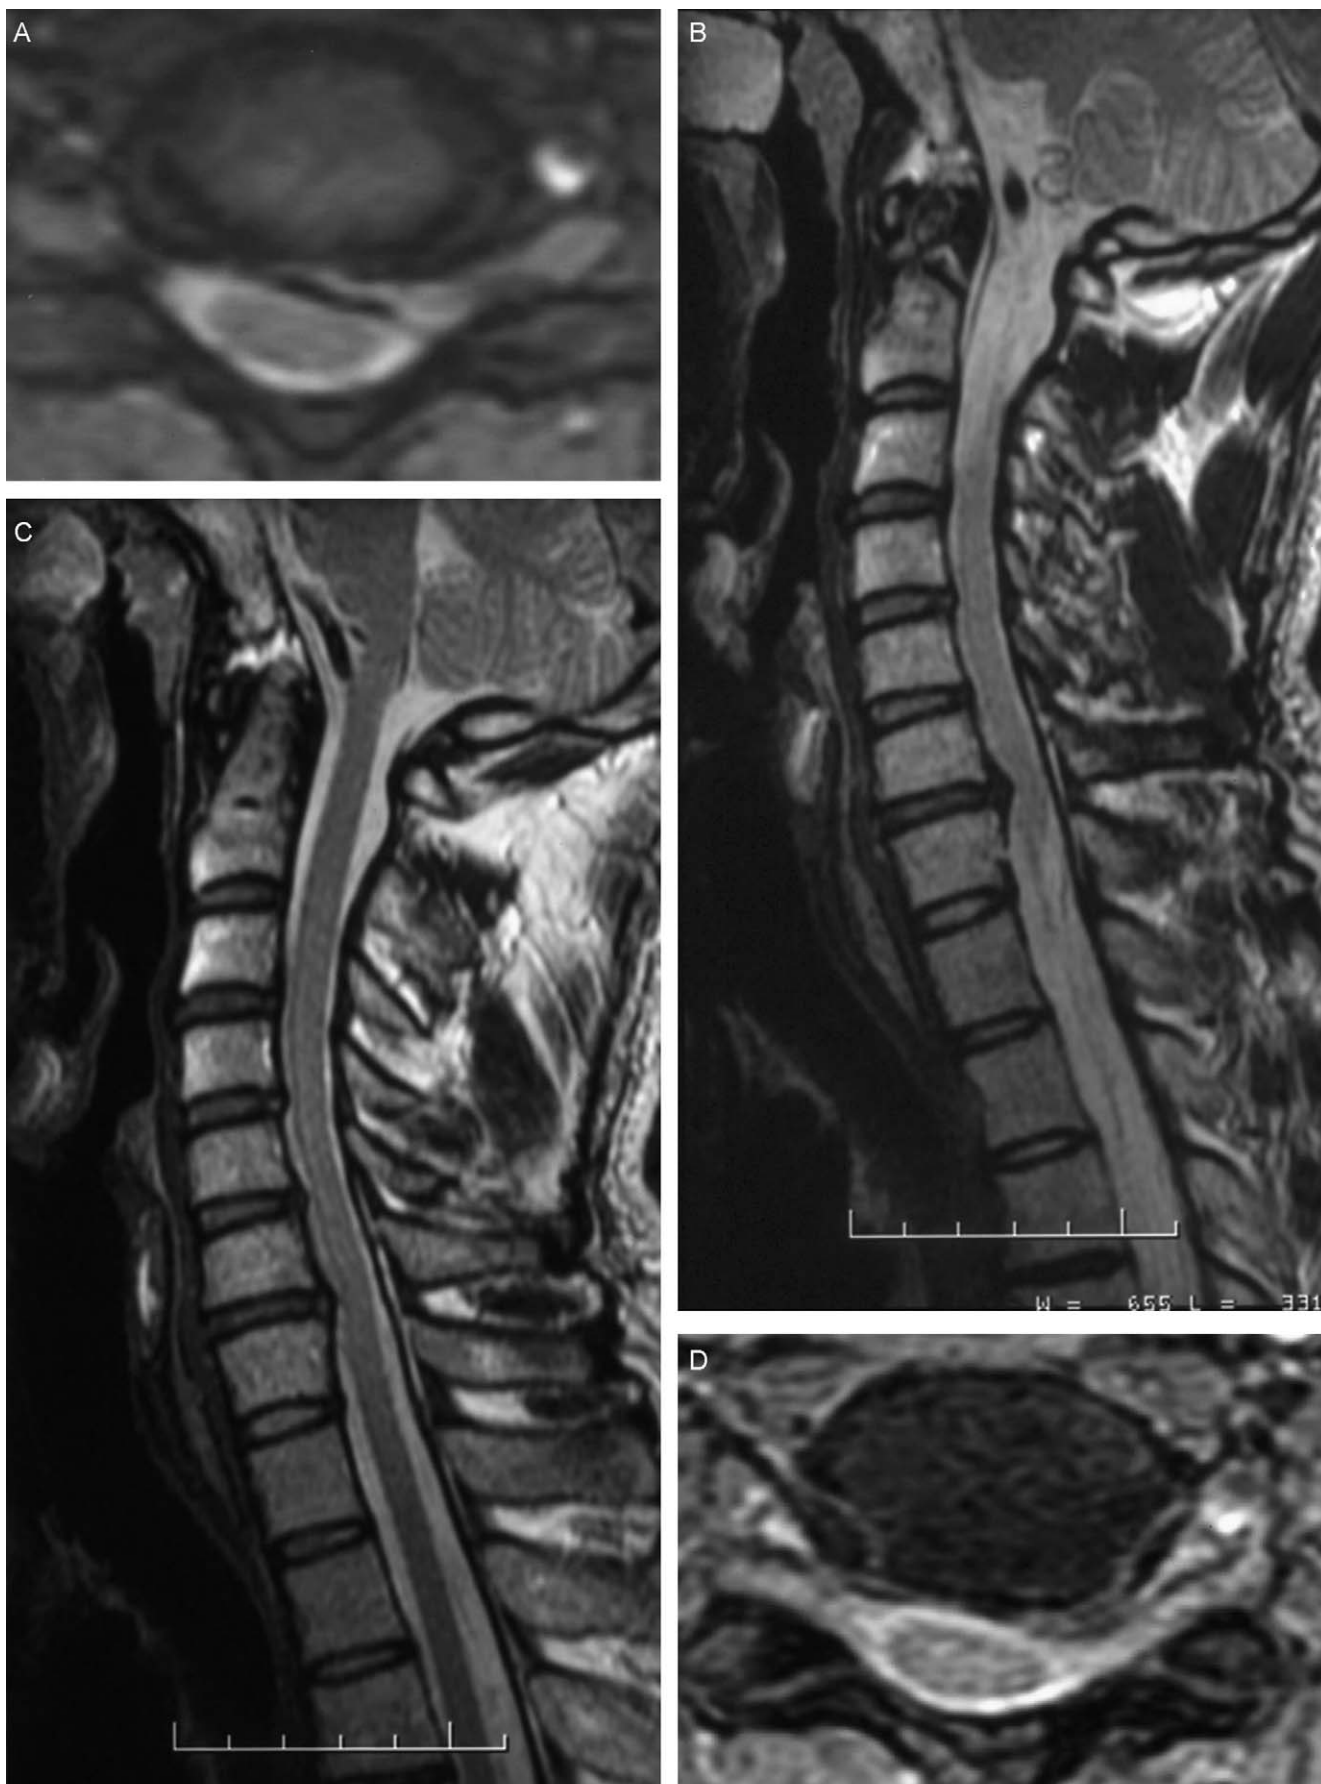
A T₂-weighted cervical axial MRI showing soft disc herniation on the left side. B T₂-weighted cervical sagittal MRI showing soft disc herniation on the C5–C6 level. C T₂-weighted cervical axial MRI, the soft disc herniation has been removed. D T₂-weighted cervical axial MRI, the soft disc herniation has been removed.
